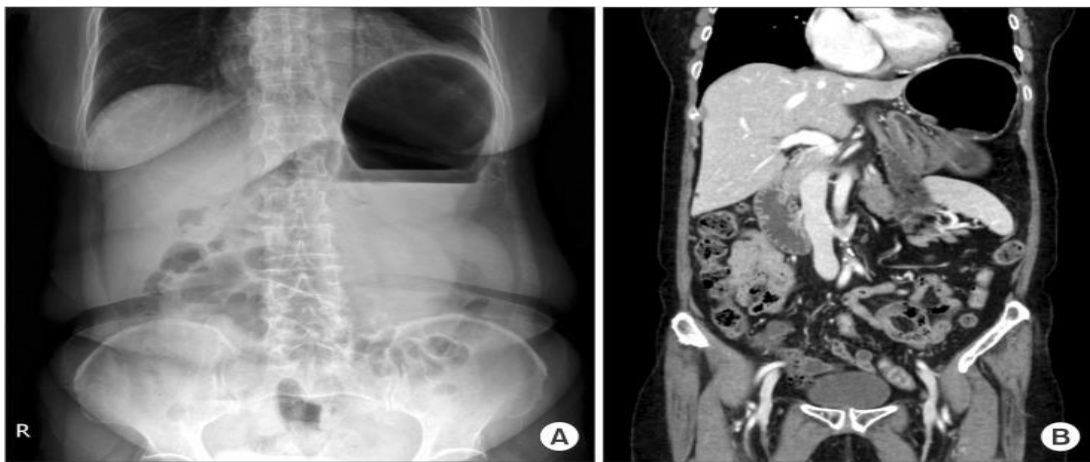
(A) simple abdominal radiograph showing a double bubble sign in the left upper abdomen. (B) markedly distended stomach with transposition of the gastroesophageal junction and gastric antrum.
